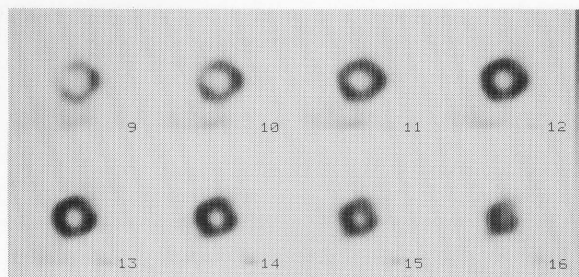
Planar and SPECT images in a 72-year-old woman. Upper panel: resting ^{201}Tl SPECT reveals normal myocardial perfusion. Lower panel: BMIPP chest anterior planar image shows no myocardial uptake.
